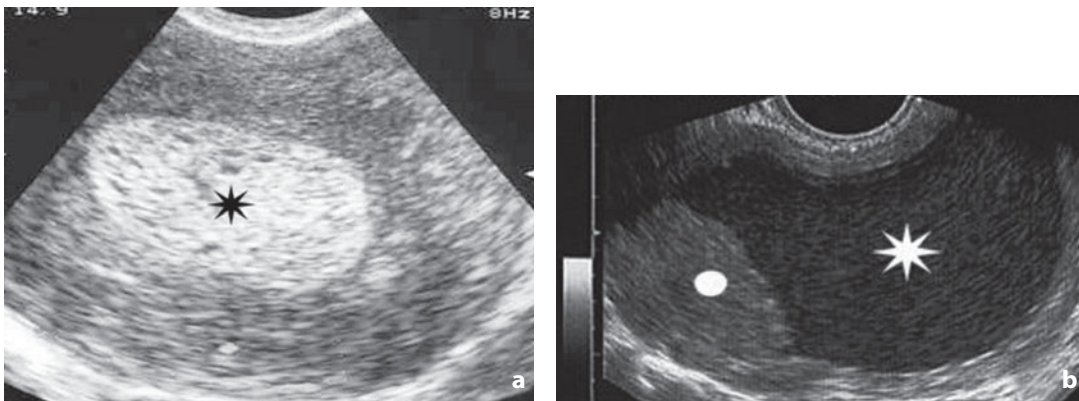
Ultrasonography. Carcinoma of the endometrium, stage IA. Transvaginal approach. a Evident widening of the endometrial cavity obstructed by hyperechoic tissue with a mildly heterogeneous structure (*asterisk*). b Different patient. The cavity is distended (*asterisk*) by corpuscular liquid (hematometra). A solid mass can be seen projecting into the lumen situated eccentrically
